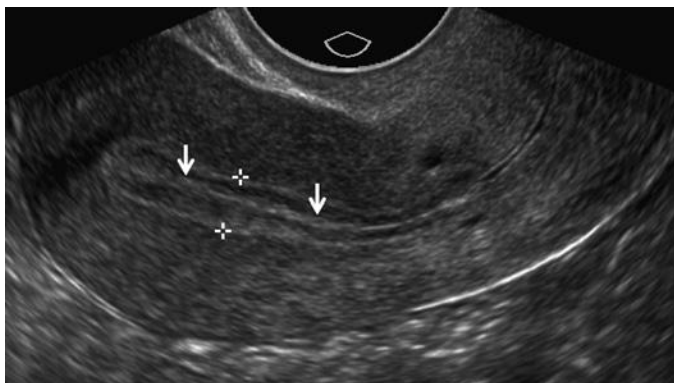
Periovulatory endometrium. Transvaginal longitudinal sonogram demonstrates the normal trilaminar appearance of the endometrium (*calipers*) in the late proliferative phase of the cycle. The basal layer of the endometrium is echogenic, but the more superficial functional layer has become hypoechoic as a result of estrogen effects. The central echogenic line (*arrows*) represents the interface where the endometrium lining the anterior and posterior walls of the uterine cavity meet.
